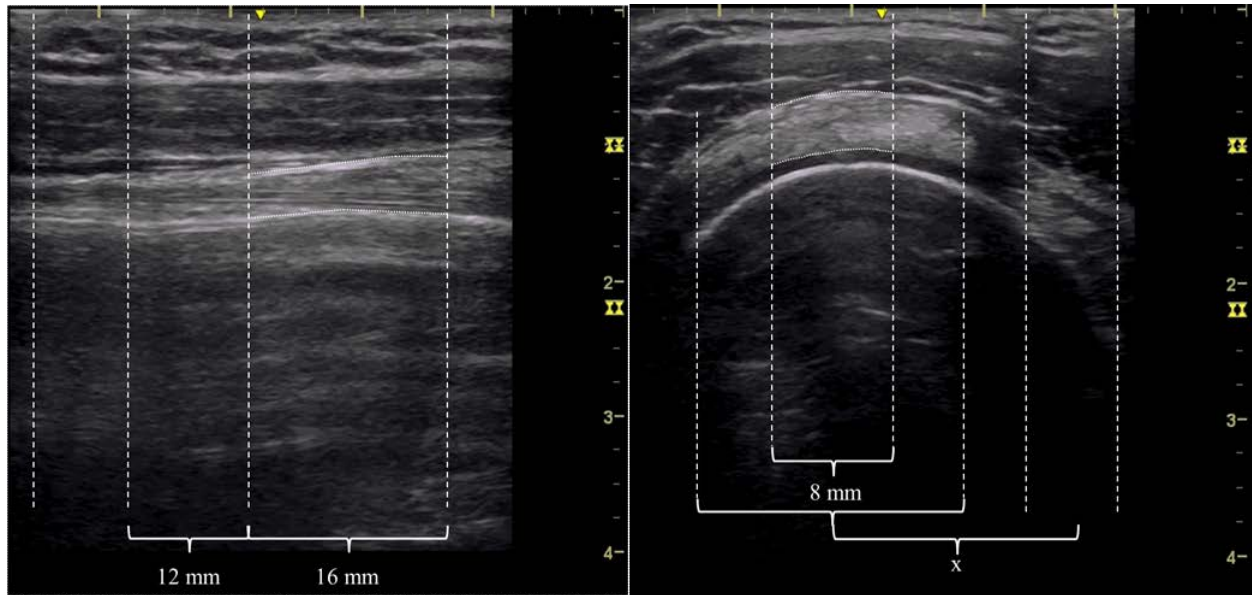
Quantitative ultrasound images of the biceps (left) and supraspinatus (right) tendons. The region of interest (ROI) is calculated from the center of the interference pattern, either 12mm for the biceps tendon or a variable distance for the supraspinatus tendon (“x”). “X” is determined when the user defines the visible portion of the tendon, and is held constant throughout the rest of the analysis using the center of the interference pattern as a reference.
